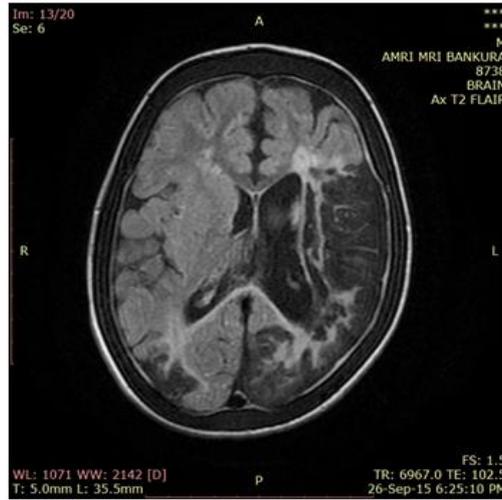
Axial T2WI FLAIR sequences taken at TR 6967ms and TE 102ms shows encephalomalacia in bilateral cerebral hemisphere (L>R) and hyper intense cortical sulci i.e. ‘Leptomeningeal “Ivy Sign” due to slow flow in engorged pial collaterals^[1,4]
